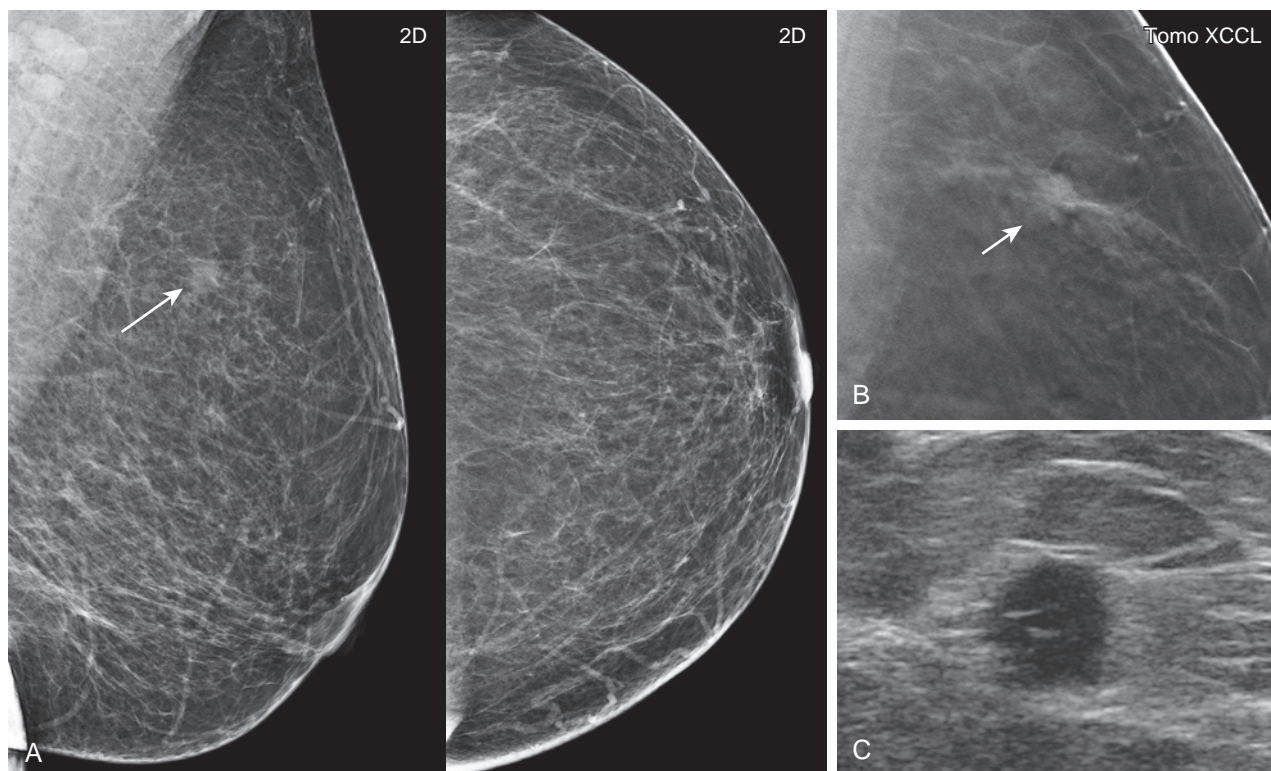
Poorly differentiated invasive ductal carcinoma presenting as developing asymmetry (A) Two-dimensional screening mammogram in a 55-year-old woman shows a new asymmetry (*arrow*) seen only in the MLO view. (B) The lesion was determined to be located in the lateral breast based on the location of the finding on the mediolateral oblique tomosynthesis slice (not shown). The lesion (*arrow*) was identified on a laterally exaggerated craniocaudal (laterally) tomosynthesis image. (C) Ultrasound shows an irregular, taller-than-wide mass with microlobulated margins. Ultrasound-guided core needle biopsy and surgical excision showed poorly differentiated invasive ductal carcinoma, ER/PR+, Her-2-, 0/3 SLN.
